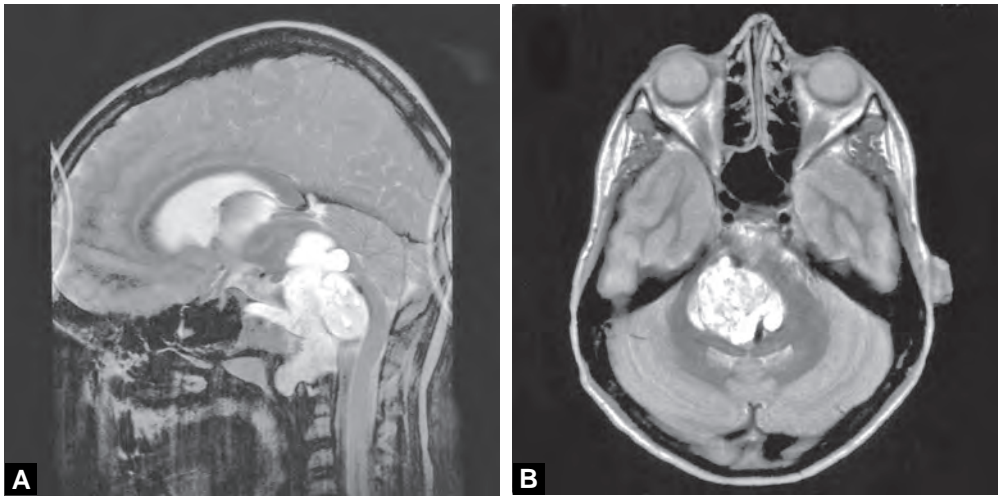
to C: MRI scan of 43-year-old man showing a large clival chordoma at the skull base
